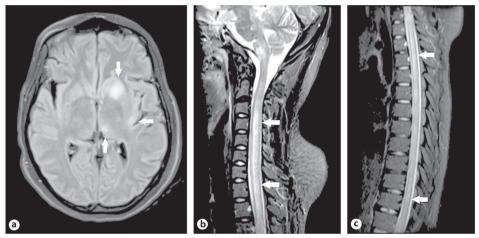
Cranial MRI of ADEM patient A. Axial Flair T2 weighed Cranial MRI showing bilateral assymmetric hyperintensities in a 57 year old female who developed neurological symptoms 15 days after symptoms compatible with an arboviral infection. ZIKV PCR was positive in blood. She was diagnosed with ADEM. B. Coronal Flair T2 weighed MRI of same patient as described in A.
